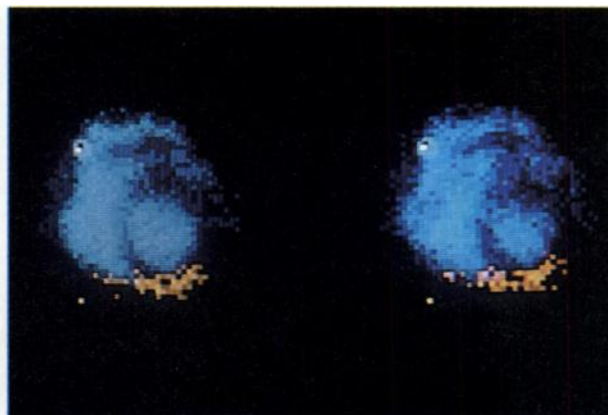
(Top, right) Tc-99m PPI myocardial scintigram obtained from patient with mild biventricular dysfunction is superimposed on blood-pool scintigram. LAO projections in diastole (left) and systole (right) show Tc-99m PPI uptake (orange) at lower portion of the ventricular septum, inferior and inferolateral portions of left ventricle, and apical aspect of right ventricle.
